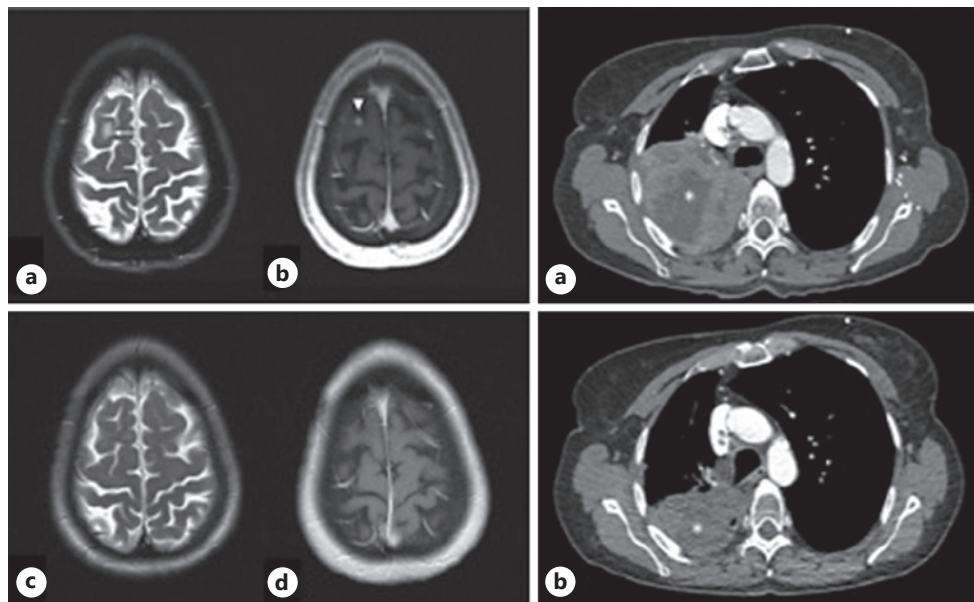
Radiological response to treatment with sotorasib. Left panel: pretherapeutic axial MR images (a: T2 weighted, b: after i.v. contrast) demonstrating a contrast-enhancing metastasis (b: arrow head) in the right frontal lobe with adjacent parenchymal oedema (a: arrow). Post-therapeutic axial MR images after 6 weeks of therapy with sotorasib showing CR (c: T2 weighted, d: after i.v. contrast). Right panel: pretherapeutic contrast-enhanced chest CT (a) demonstrating a locally advanced primary tumour (*) of the right upper pulmonary lobe with PR after 6 weeks of therapy with sotorasib (b).
